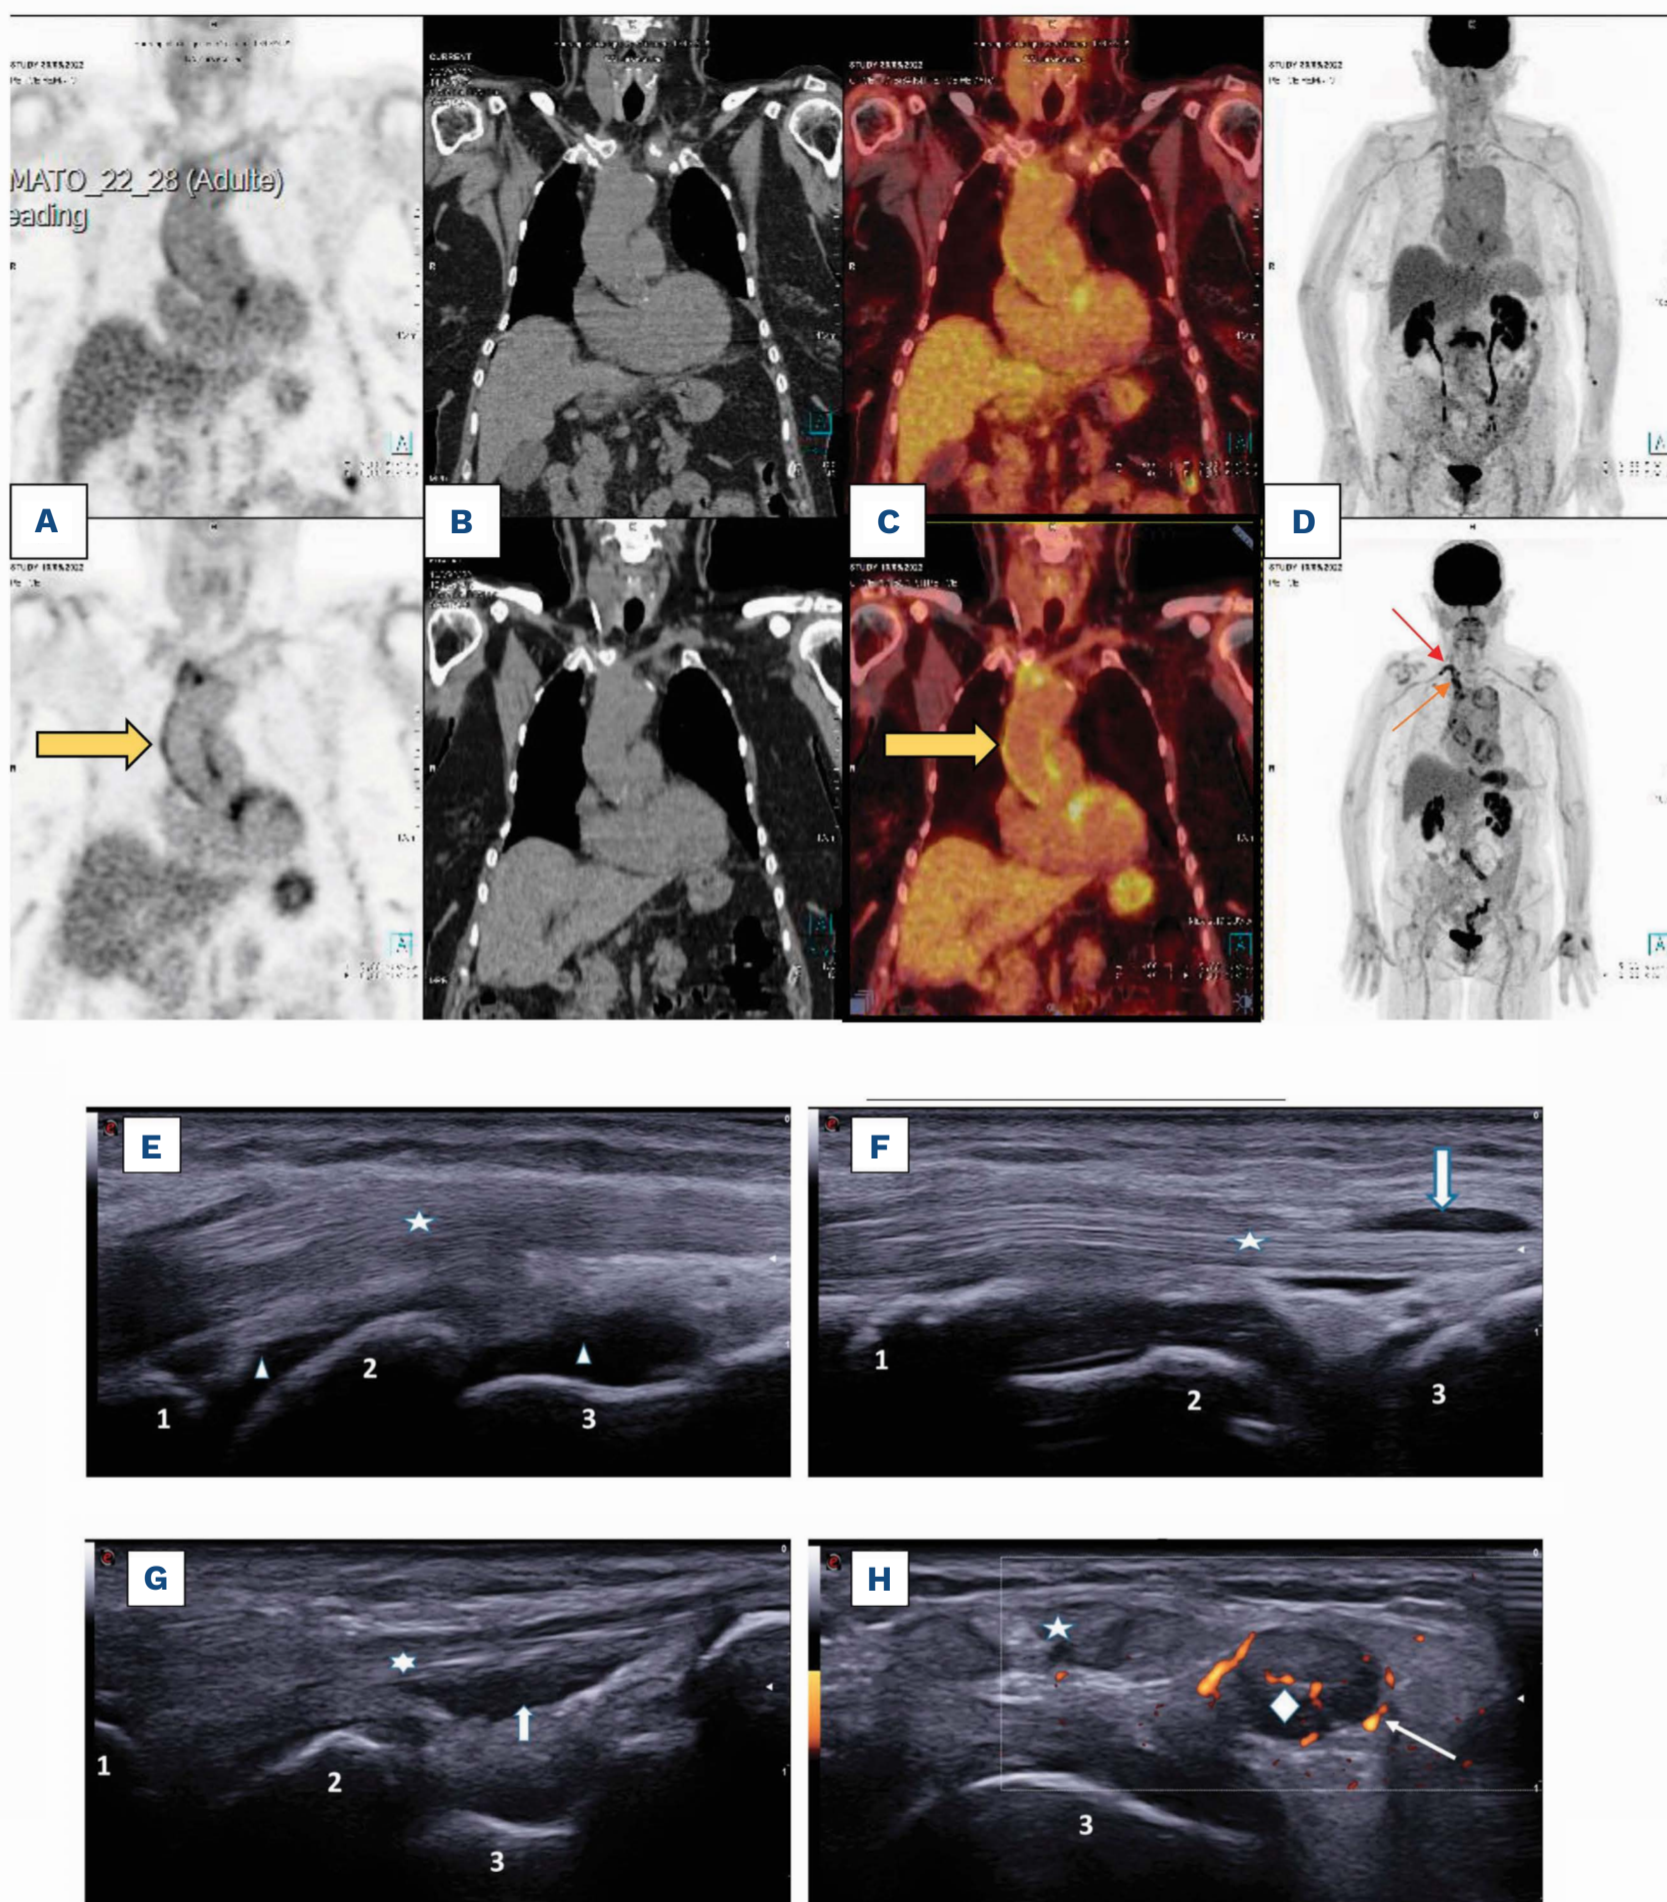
Positron emission tomography and ultrasound pictures of the two cases. (A-D) Positron emission tomography (PET)-computed tomography (CT) scans showing grade 3 parietal hypermetabolism of the thoracic aorta, brachiocephalic artery trunk, right subclavian artery, and left common iliac artery. Case 1 : (A) PET coronals, (B) CT coronals, (C) fused coronals, (D) whole body PET. Top row: after corticotherapy; bottom row: before corticotherapy. Red arrow: right subclavian artery hypermetabolism; orange arrow: right brachiocephalic trunk hypermetabolism. Case 2 (E-H): (E) right radiocarpal synovitis, longitudinal section (B mode), (F) right tenosynovitis, extensor digitorum communis (B mode), (G) right tenosynovitis, flexor digitorum communis (B mode), (H): right tenosynovitis, extensor digitorum brevis and extensor digitorum longus with Doppler hyperemia. Triangle stands for radial and medial carpal synovitis (E only). Numbers 1, 2, and 3, respectively stand for radius, lunatum, and capitatum; five- and six-pointed stars respectively stand for extensor digitorum communis, and flexor digitorum communis (G). Diamond in (H) stands for the extensor digitorum brevis and the extensor digitorum longus. Large arrow in (F, G) highlights synovitis effusion around tendon sheaths. Thin arrow in (H) demonstrates doppler vascularization.
